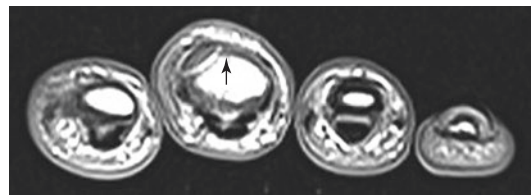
Axial T1-weighted MRI: hyperintense fracture line in the middle phalanx base Dig. 3
